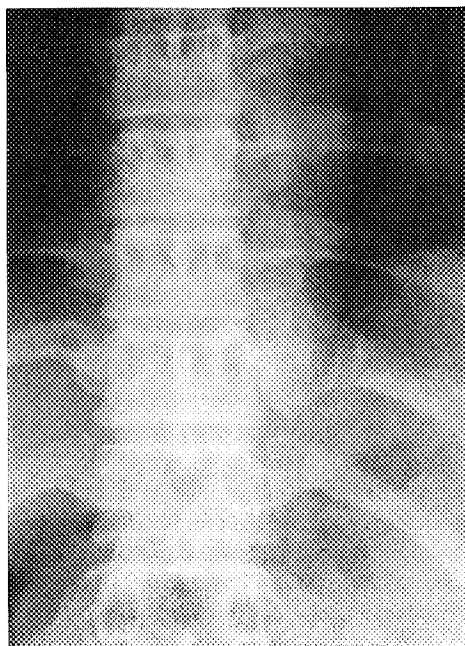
Plain radiograph of the thoracic spine showing an osteolytic, bubble-like lesion.
